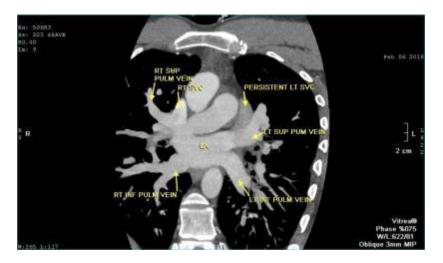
multi slice CT, showing the connection of pulmonary veins to the LA, and the right superior PV to the SVC.
